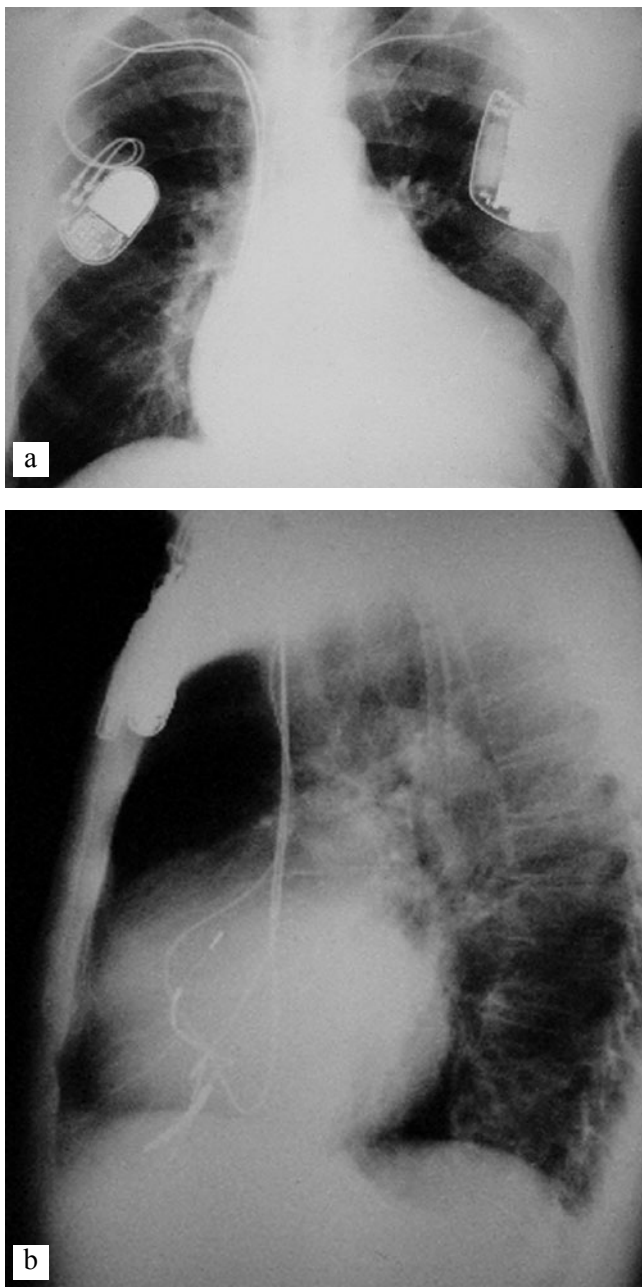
Thoracic X-rays of the bifocal pacing system (panel a) and of the implanted single-chamber ICD (panel b).
